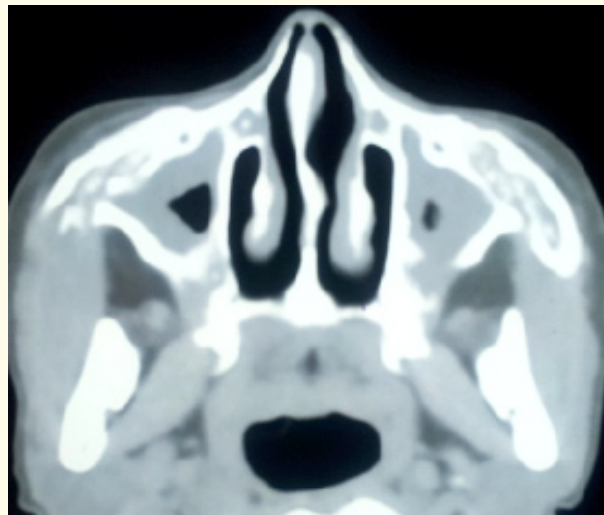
Axial CT section reveals expansion of the zygomatic arches bilaterally with sequestration in the medullary cavity and associated periosteal reaction with cortical thickening.
